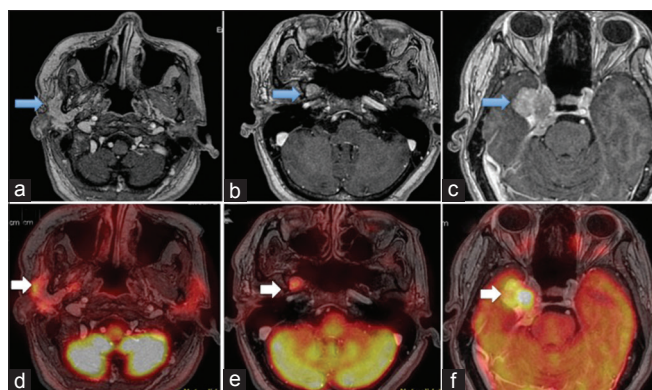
(a-c) Sequential postcontrast transaxial magnetic resonance imaging (MRI) images showing diffuse homogeneous enhancement from the right parotid gland extending along the thickened mandibular nerve upto the right middle cranial fossa (MCF) and prepontine cistern. (d-f) Sequential transaxial fused PET/MR images showing increased FDG uptake in the well-defined nodular lesion in the right parotid with contiguous curvilinear FDG uptake noted along the thickened mandibular nerve, extending up to the mass lesion in the MCF
